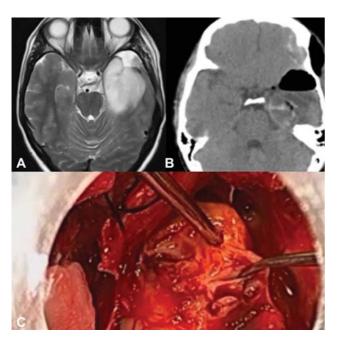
(A) Axial T2 weighted magnetic resonance imaging showing the heterogenous hyperintense lesion in the anterior temporal lobe showing ill-defined margins. (B) Axial computed tomography image showing postoperative changes in the left temporal lobe and foci of air in the operative bed. (C) Intra operative endoscopic view during tumor excision showing partly fibrous tumor.
